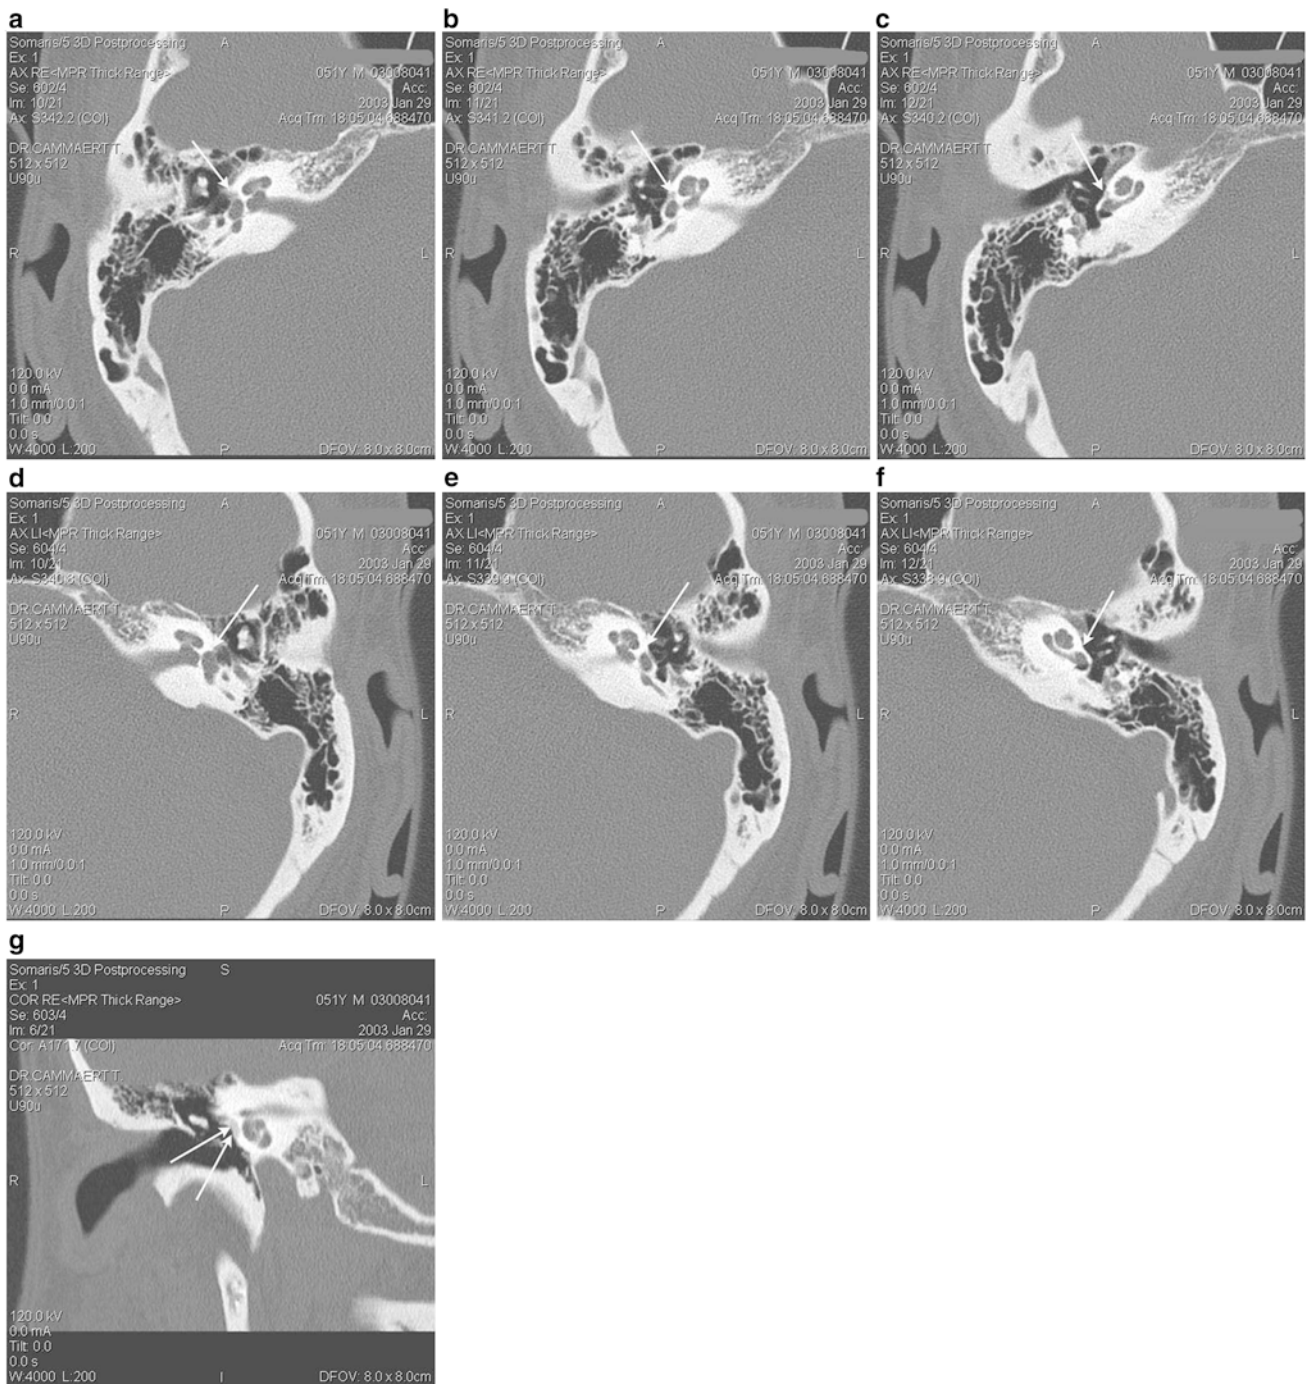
In the right ear three consecutive CT images (a–c) show a lucent area just anterior to and extending to the oval window: fenestral otosclerosis (arrow). In the same patient, the normal contralateral ear
